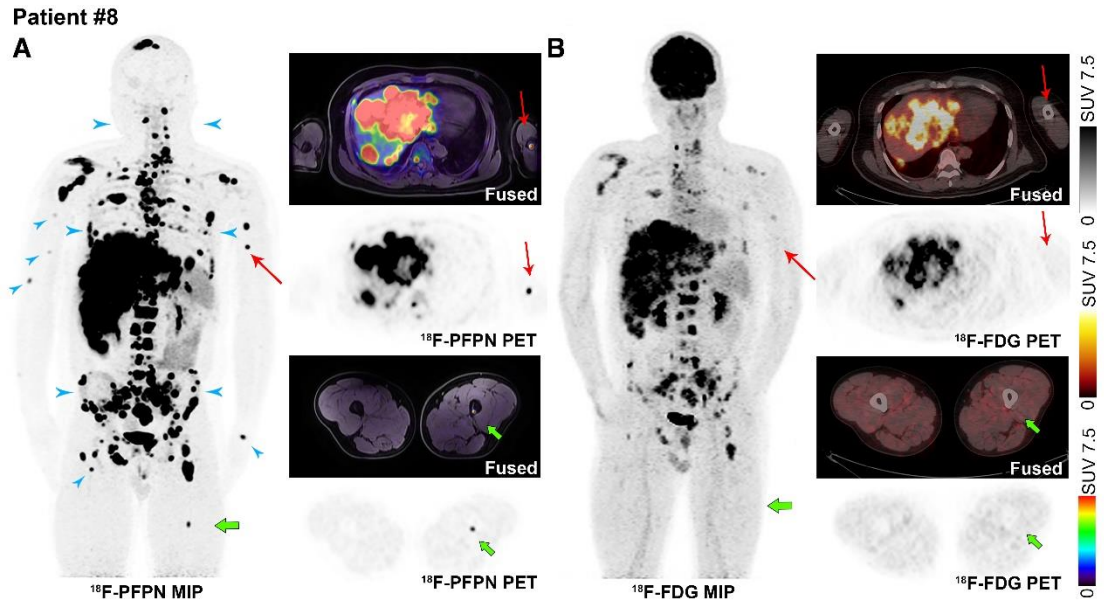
A 47-year-old man had undergone surgical removal of a choroidal MM 19 months before imaging. On MIP images,  $^{18}\text{F}$ -PFPN PET (A) was able to identify a higher number of lesions (blue arrowheads) compared with  $^{18}\text{F}$ -FDG PET (B).  $^{18}\text{F}$ -PFPN PET/MR identified a hyper-intense T1WI focus of increased tracer uptake in the left arm (SUVmax: 8.4, red arrows) and left femur (SUVmax: 6.8, <2-mm, green arrows), which had normal uptake and density on  $^{18}\text{F}$ -FDG PET/CT images.
